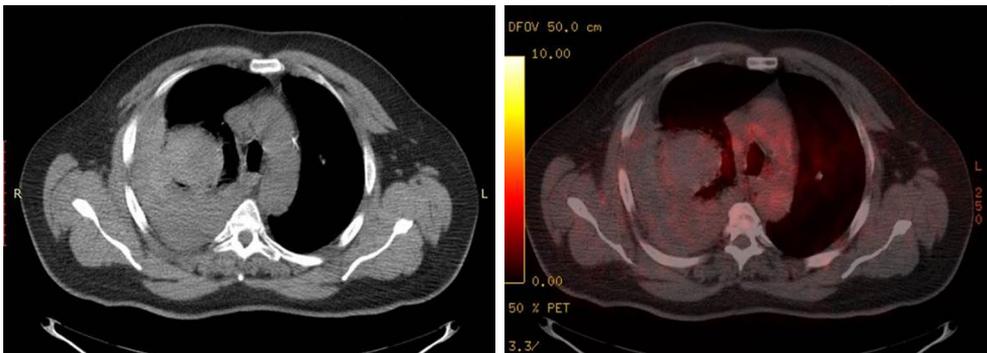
In PET/CT, a 60×55 mm hypodense lesion in the right upper lobe posterior segment with minimal FDG involvement (SUV_{max} : 2.9) is observed at the periphery, while pleural fluid with 63 mm thickness (SUV_{max} : 2.4) is observed in the right hemithorax.
